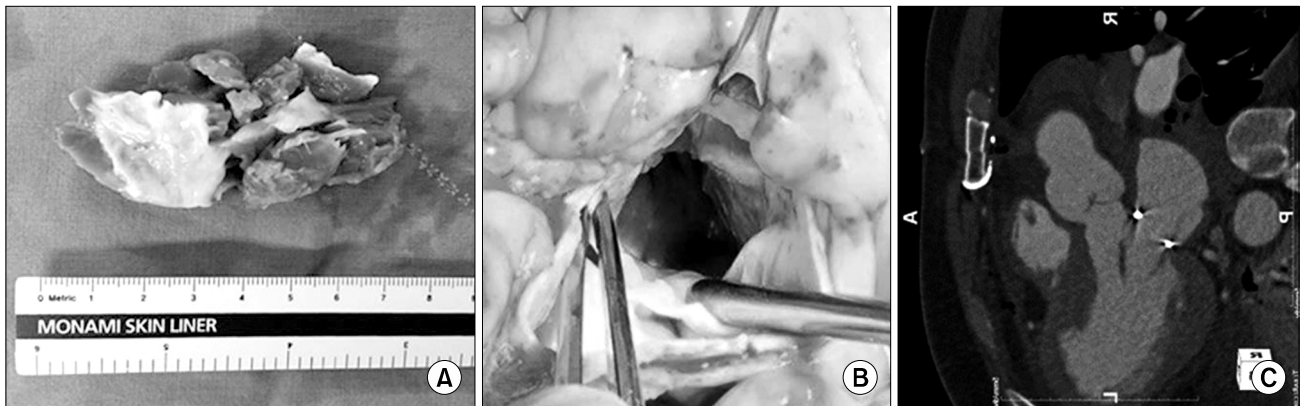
(A) Operative photo showing the resected muscle (weight, 12 g). (B) Operative photo showing the relieved left ventricular outflow tract. (C) Postoperative heart computed tomogram showing the relieved left ventricular outflow tract.
